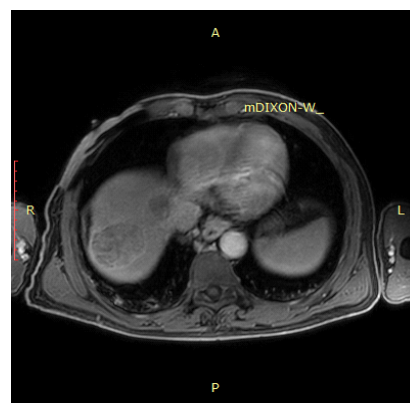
MRI of the liver, showing the primary heterogeneous HCC lesions, arterial contrast uptake and late washout, characteristic of primary liver tumors derived from hepatocytes.
